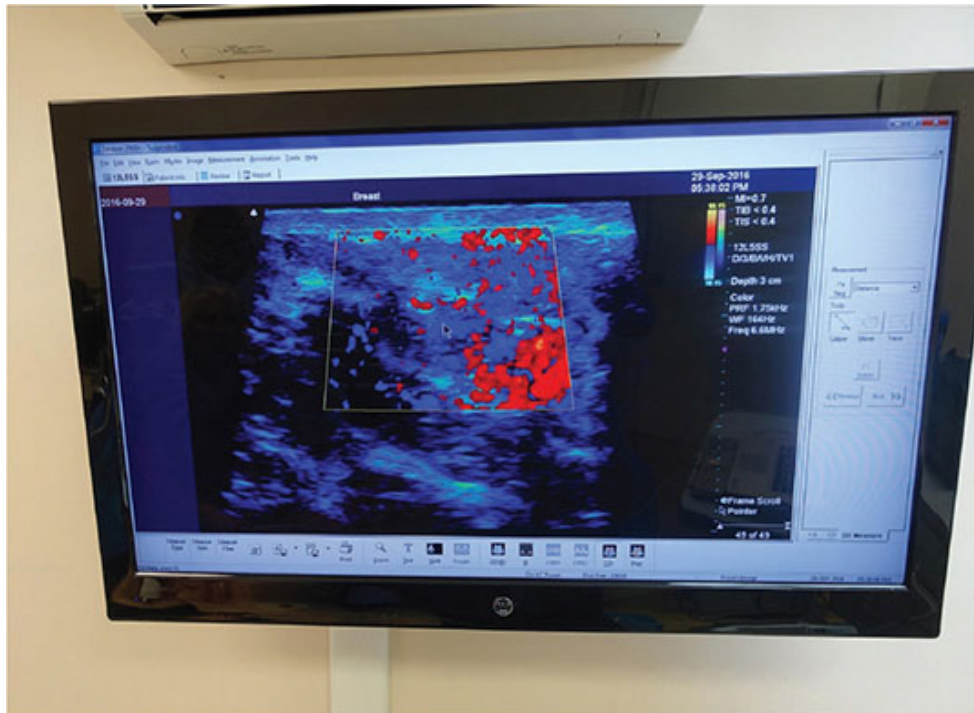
The ultrasound image of the recipient site can reveal blood vessel location and detect fat injection.
